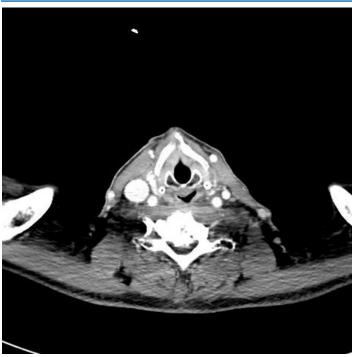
Contrasted neck CT at 12 months postchemoradiotherapy showed improved nonenhancing ulceration without disease progression.
